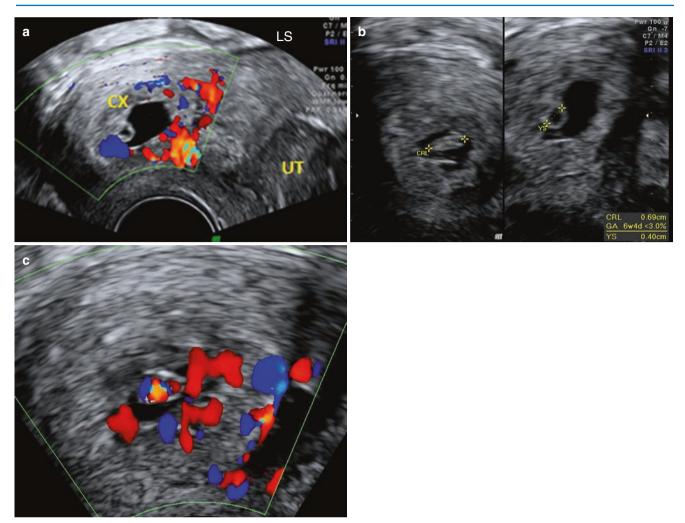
Live cervical ectopic pregnancy. (a) Ballooned-out cervix with the ectopic pregnancy mass, within, that showed a central cystic area with vascular trophoblastic tissue surrounding it. (b) Fetal pole and yolk sac are seen within. (c) Fetal heart pulsations detected on Doppler
